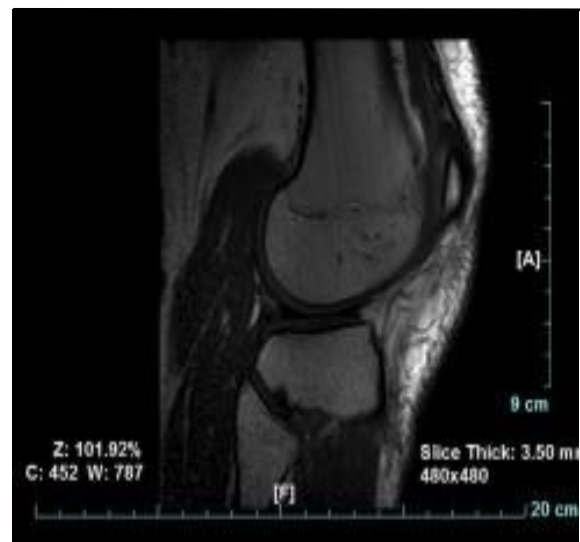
Radiographic knee showing joint deformity Secondary Heterogeneity of surrounding soft tissues (early phase ). [18]
